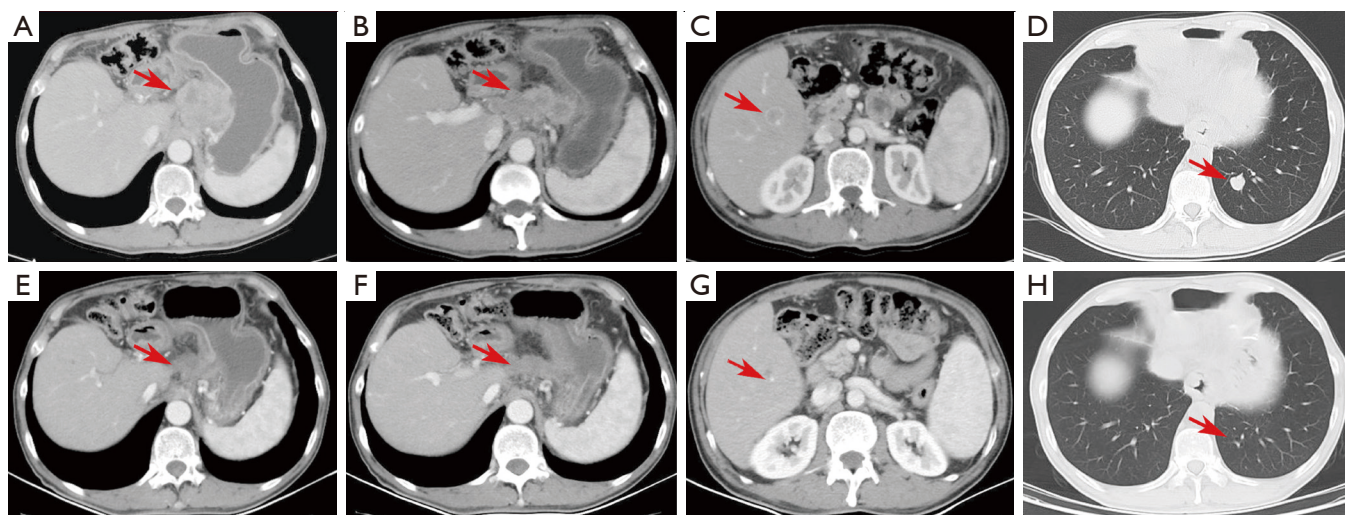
Imaging findings of response after combination immunotherapy. (A) The abdominal CT scan showed a thickening wall of lesser curvature and multiple enlarged peri-gastric lymph nodes (54 mm × 47 mm). (B) Enlarged lymph nodes (28 mm × 28 mm) surrounding the celiac trunk. (C) Isolated intrahepatic nodule (18 mm × 14 mm). (D) Nodules in the lower lobe of the left lung (14 mm × 13 mm). (E) The thickening wall of lesser curvature and peri-gastric lymph nodes shrunk (26 mm × 22 mm). (F) Reduced size of lymph nodes (18 mm × 18 mm) surrounding the celiac trunk. (G) Reduced size of the intrahepatic nodule (7 mm × 5 mm). (H) Nodules in the lower lobe of the left lung grew down to almost disappeared (14 mm × 13 mm). (A) to (D) were generated before combination therapy (2019-4-10); (E) to (H) were generated after 2 cycles of combination immunotherapy (2019-5-28).
